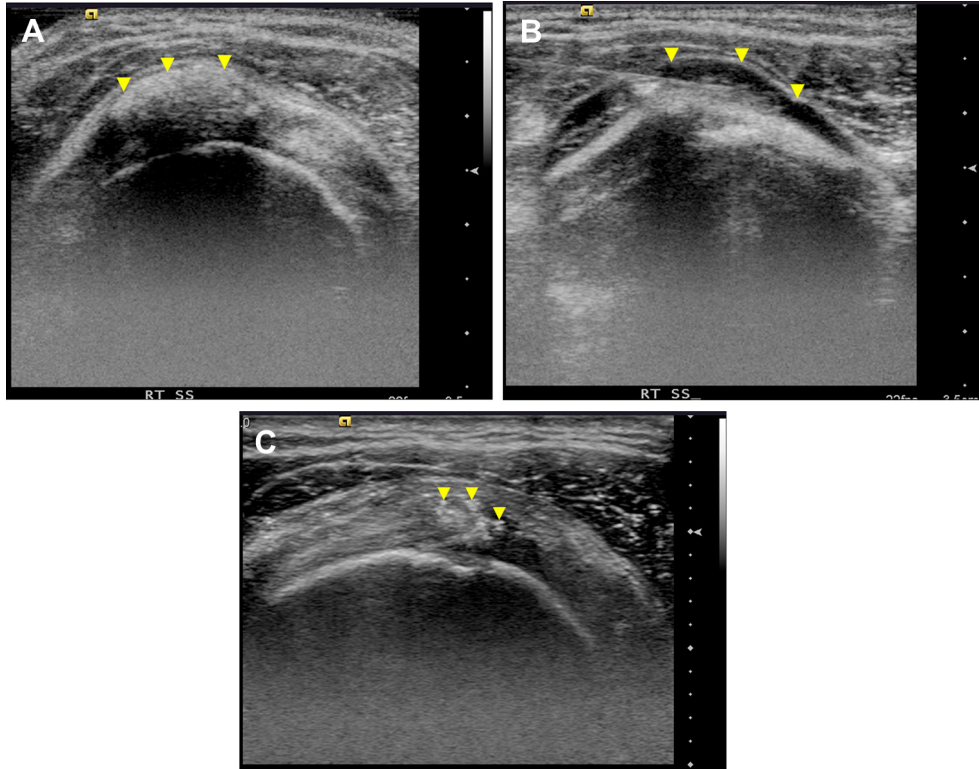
A 41-year-old female complained of right shoulder pain for 1 year. Ultrasonography showed a nodular calcification in the right supraspinatus tendon (arrowheads in A). After ultrasonography (US)-guided repeated puncture, 1 mL of xylocaine with 1 mL of corticosteroid was injected into the right subdeltoid bursa (arrowheads in B). Six months later, ultrasonography showed a cluster of punctate calcification spots, with >50% reduction in calcification (arrowheads in C), and the patient reported marked reduction of pain.
